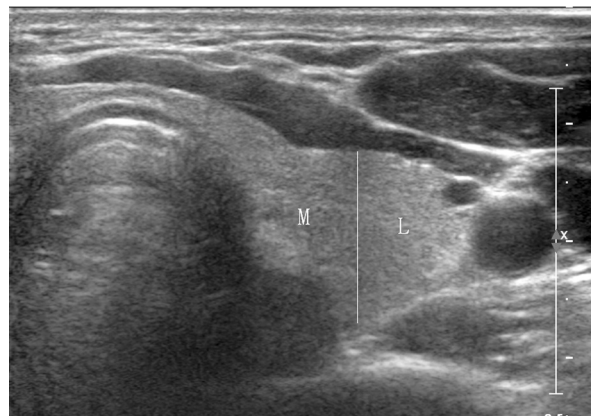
Ultrasonographic axial view of the left thyroid lobe. The axial view of the left lobe was equally divided into the medial (M) and lateral (L) portions.
